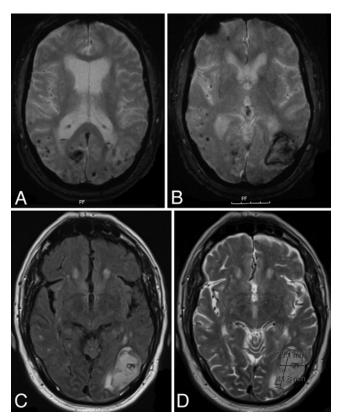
A: Magnetic resonance image of the brain demonstrating dot burden on a gradient echo sequence. B: Gradient echo sequence demonstrating acute CAA-associated ICH in the left parietooccipital region. C: A FLAIR sequence showing acute CAA-associated ICH. D: Axial T2-weighted image showing the extent of acute CAA-associated ICH in the left parietooccipital region.
